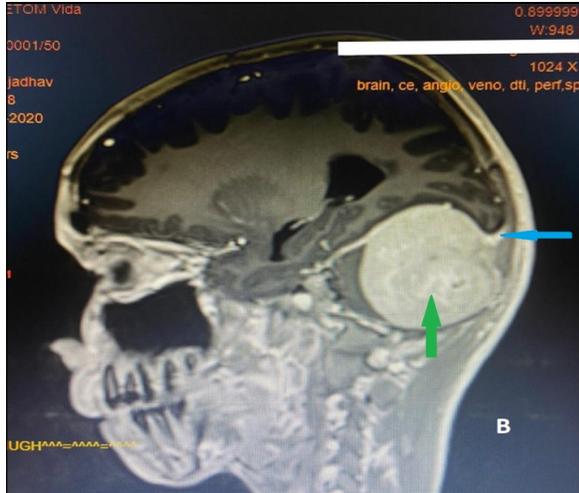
Post Gadolinium enhanced MRI (sagittal) T1 weighted image shows lesion (green arrow) with dural tail (blue arrow).
